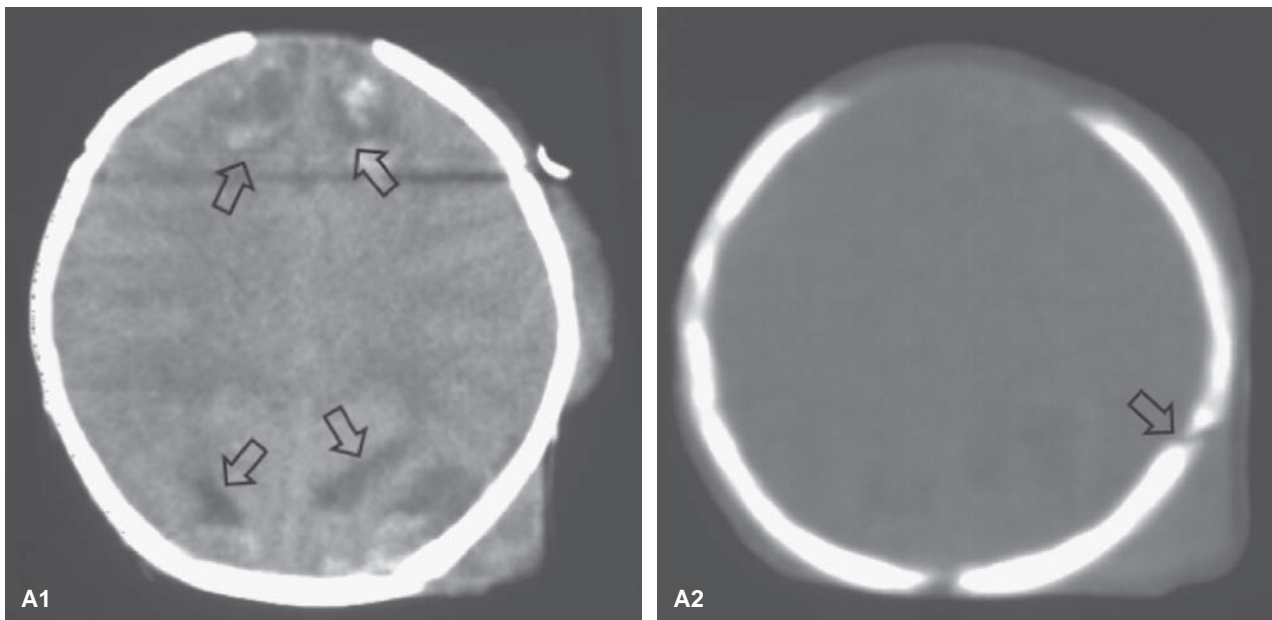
A: Six-week-old infant examined by computed tomography (CT) without contrast. A1: Axial CT shows focal areas of increased and decreased density in the anterior and posterior parasagittal regions (*arrows*). Scalp swelling is present on the left. A2: Axial bone window shows fracture of the right parietal bone (*arrow*). (*continued*)
